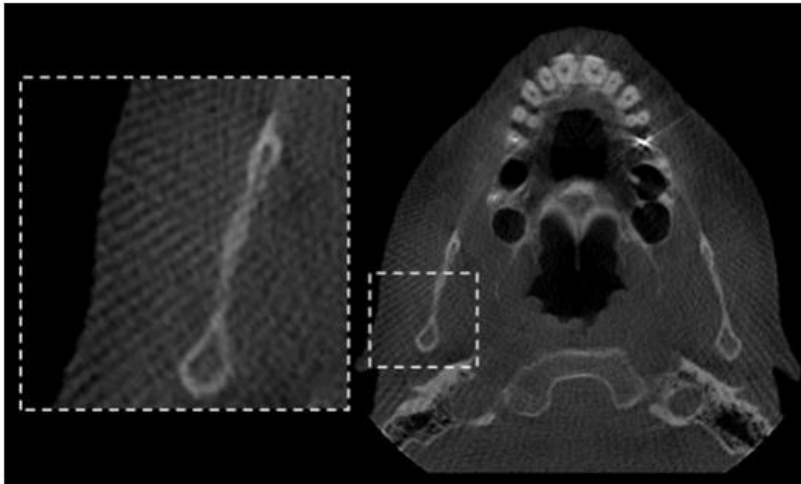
On the periphery of CBCT image, fine alternating hyperdense and hypodense stripes are seen radiating from the edge of the volumetric data, resulting in “Moiré” pattern, which is a type of aliasing artifact. ^[1]
